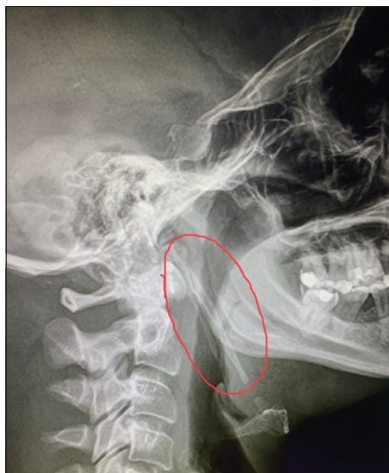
Lateral neck X-ray. The elongated styloid process extends from the tympanic plate of the temporal bone to the hyoid cartilage (circle enclosing) (Eagle's syndrome)
